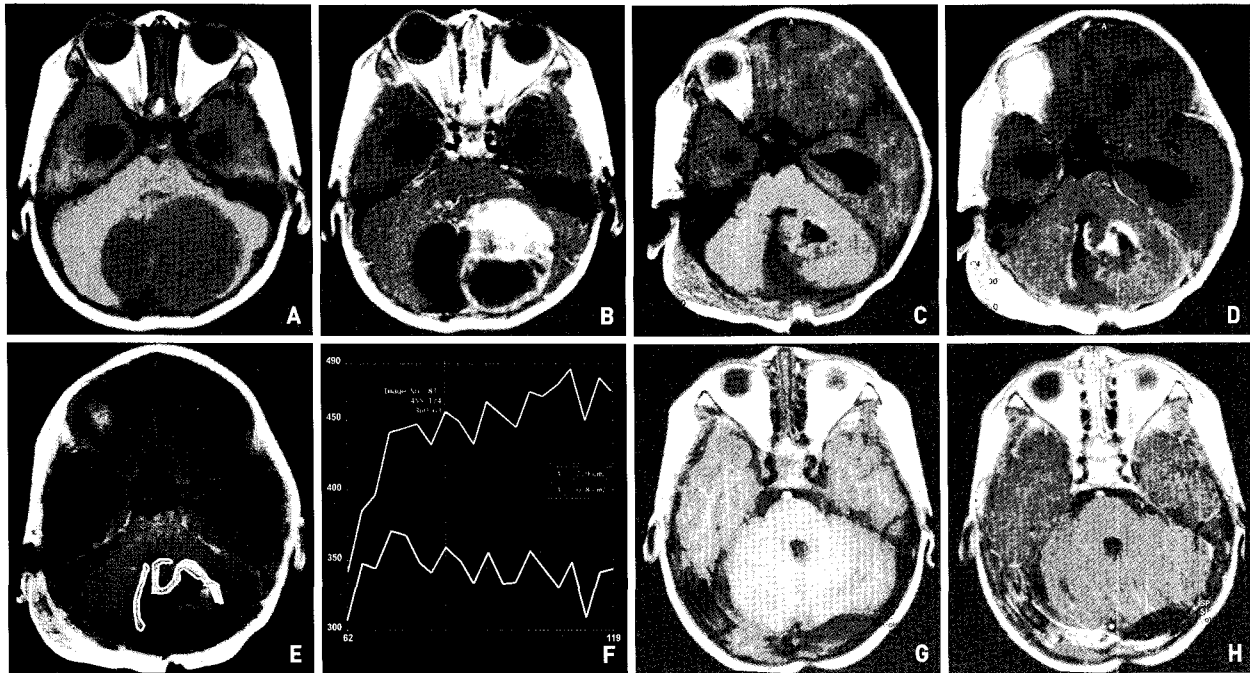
A 1-year-old male patient with pilocytic astrocytoma (case 10). A : T1-weighted image shows low-signal intensity in the posterior fossa. B : Heterogenous enhancement and cystic changes are noted after administration of Gd-DTPA. C : T1-weighted image of the magnetic resonance image taken on the first postoperative day. D : After administration of Gd-DTPA, enhancement is noted along the periphery of the tumor. E : Region of interest on the tumor remnant (yellow) and surrounding (white) areas. F : "T pattern" is noted in the tumor remnant area (yellow curve) and "N pattern" is noted in the surrounding area (white curve). G : T1-weighted image of magnetic resonance image taken 2 year later. H : No evidence of enhancement is noted after administration of Gd-DTPA.
